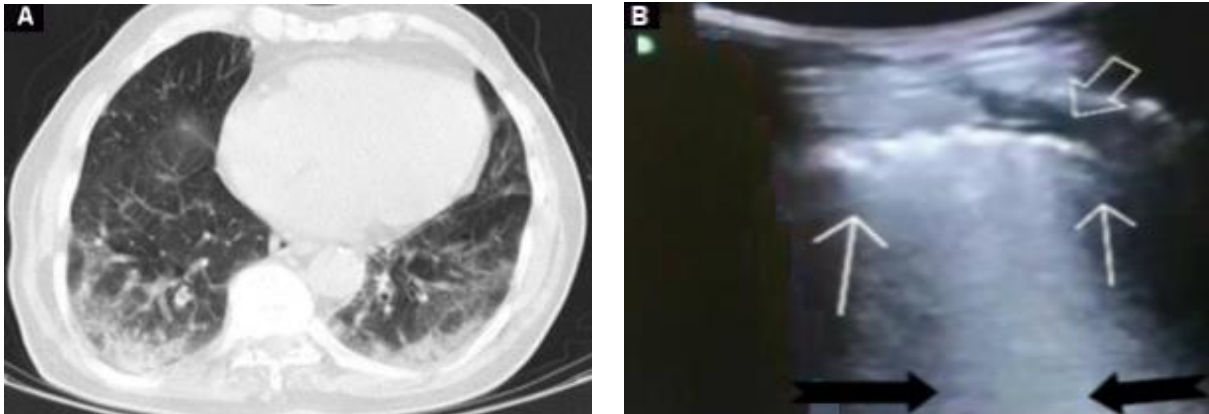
(A) CT scan with GGO and consolidation in the RLL and LLL. (B) US with B₂ lines (black arrows), pleural irregularity (thin arrows), and mild pleural effusion in the RLL (open arrow). RLL: Right Lower Lobe, LLL: Left Lower Lobe, GGO: Ground Glass Opacity.
